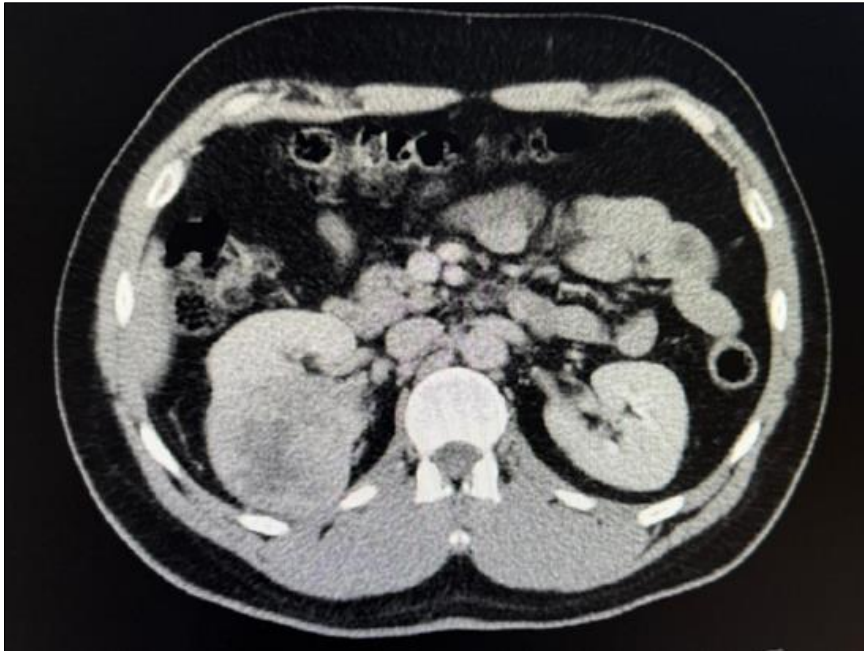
Contrast-enhanced CT scan revealing a 6.7 cm renal mass located at the lower pole of the left kidney
